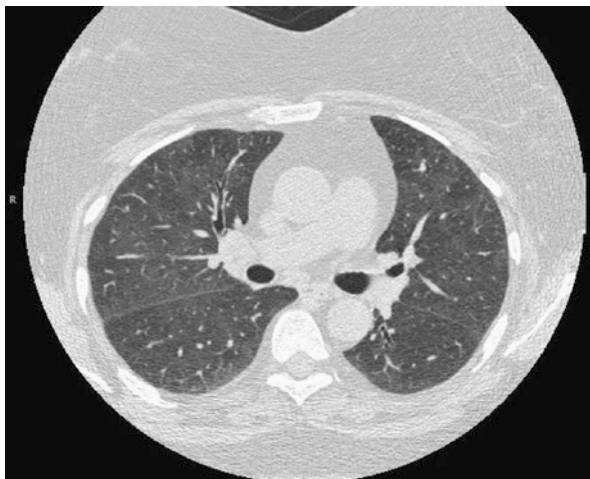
Chest CT: there is a diffuse ground glass appearance throughout the lungs without fibrosis
